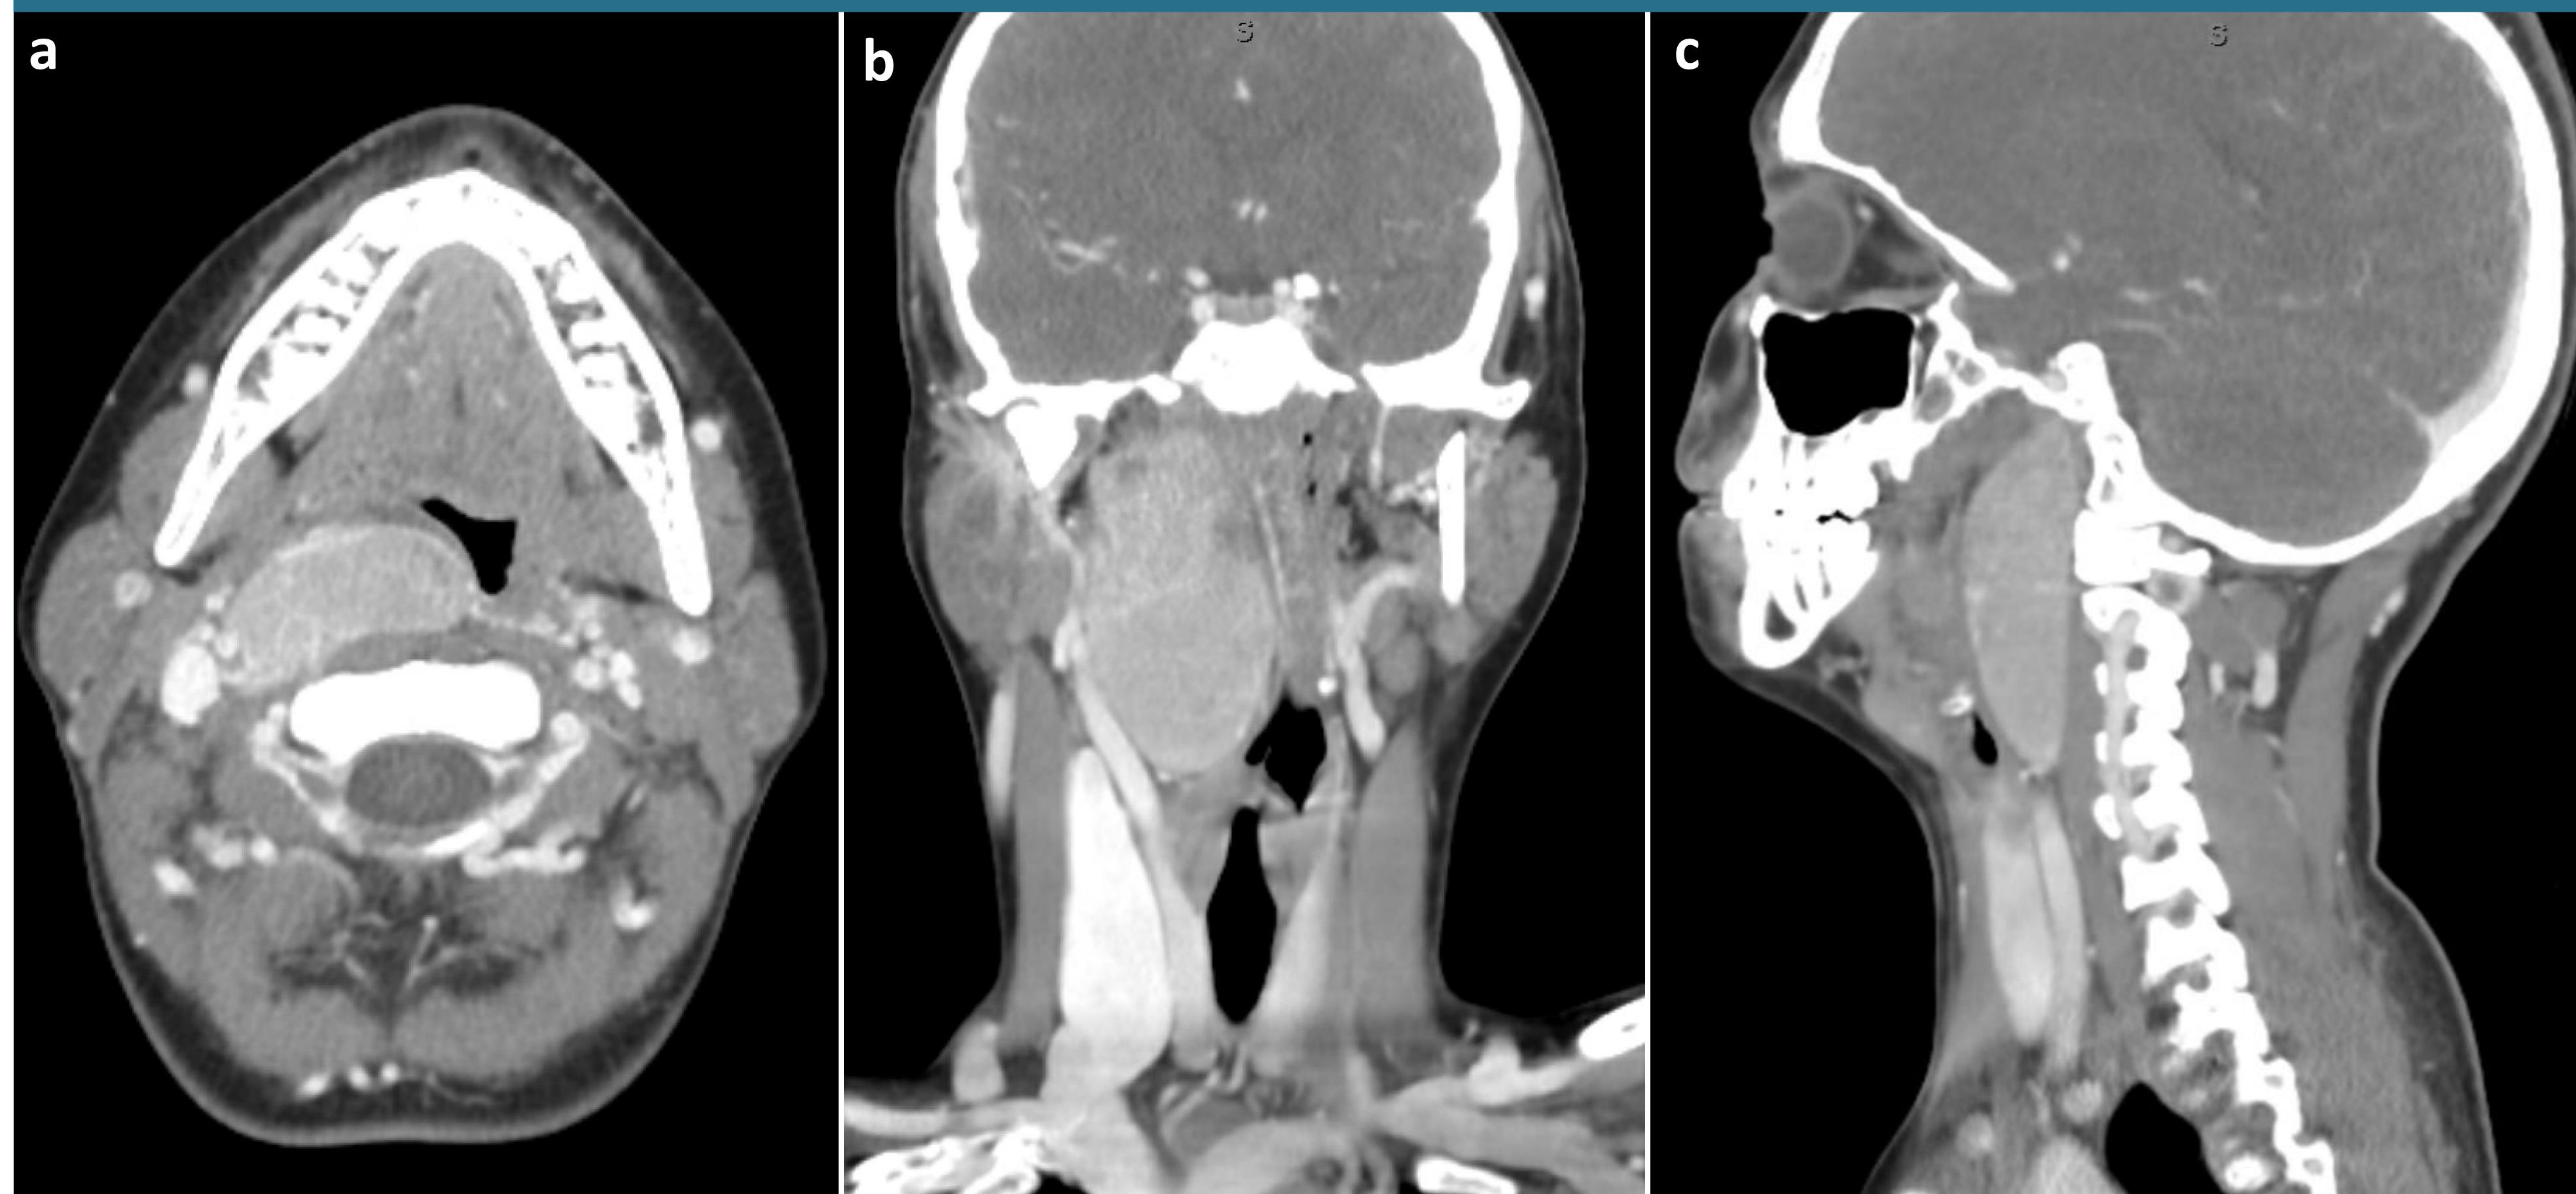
(a) axial (b) coronal and (c) sagittal CT images with contrast: 7.6cm parapharyngeal mass extending from skull base to base of tongue
